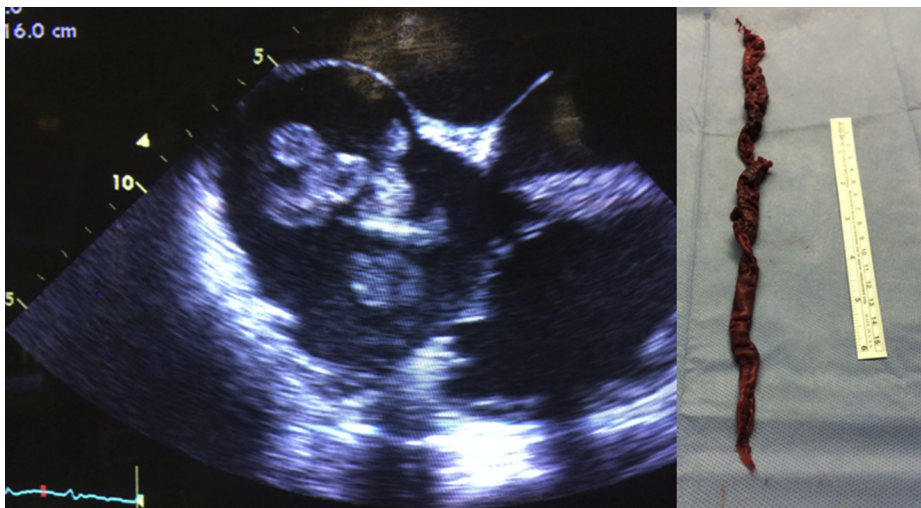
A large intracardiac thrombus as visualized by transesophageal echocardiography was successfully removed using the AngioVac device.
